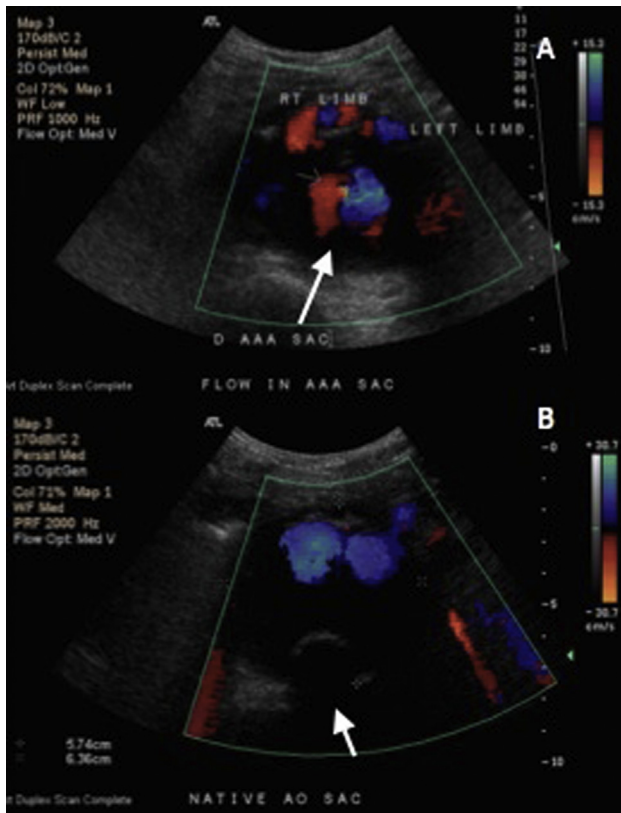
Preoperative ultrasound of patient with flow seen into the abdominal aortic aneurysm sac as well as within the right and left limbs of the bifurcated Dacron graft. The arrow points to the area of endoleak (A). Postoperative image indicating Type 2 endoleak repair with no flow from the lumbar vessels into the aneurysm sac, with flow seen in both limbs. The arrow points to location of the Onyx injection (B).
